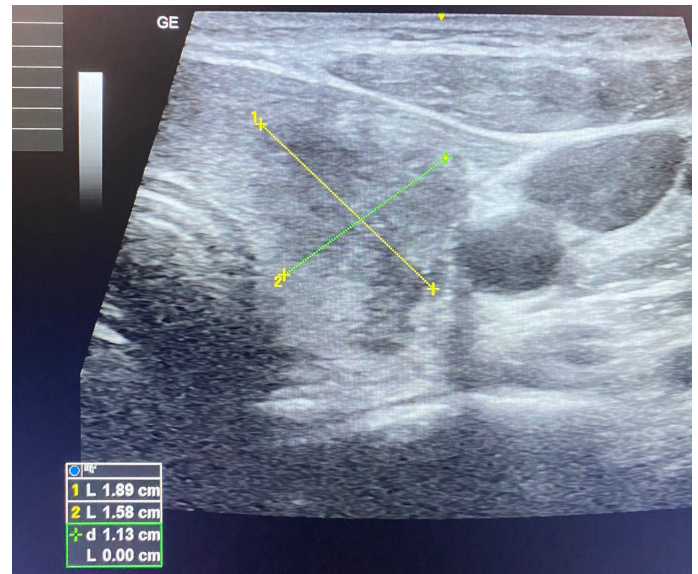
Ultrasonographic image of the case.
